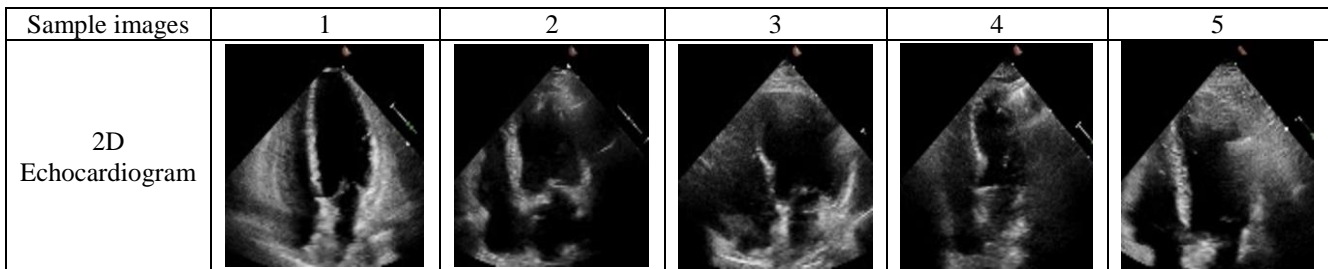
Sample 2D echocardiogram images for Atrial Fibrosis segmentation
